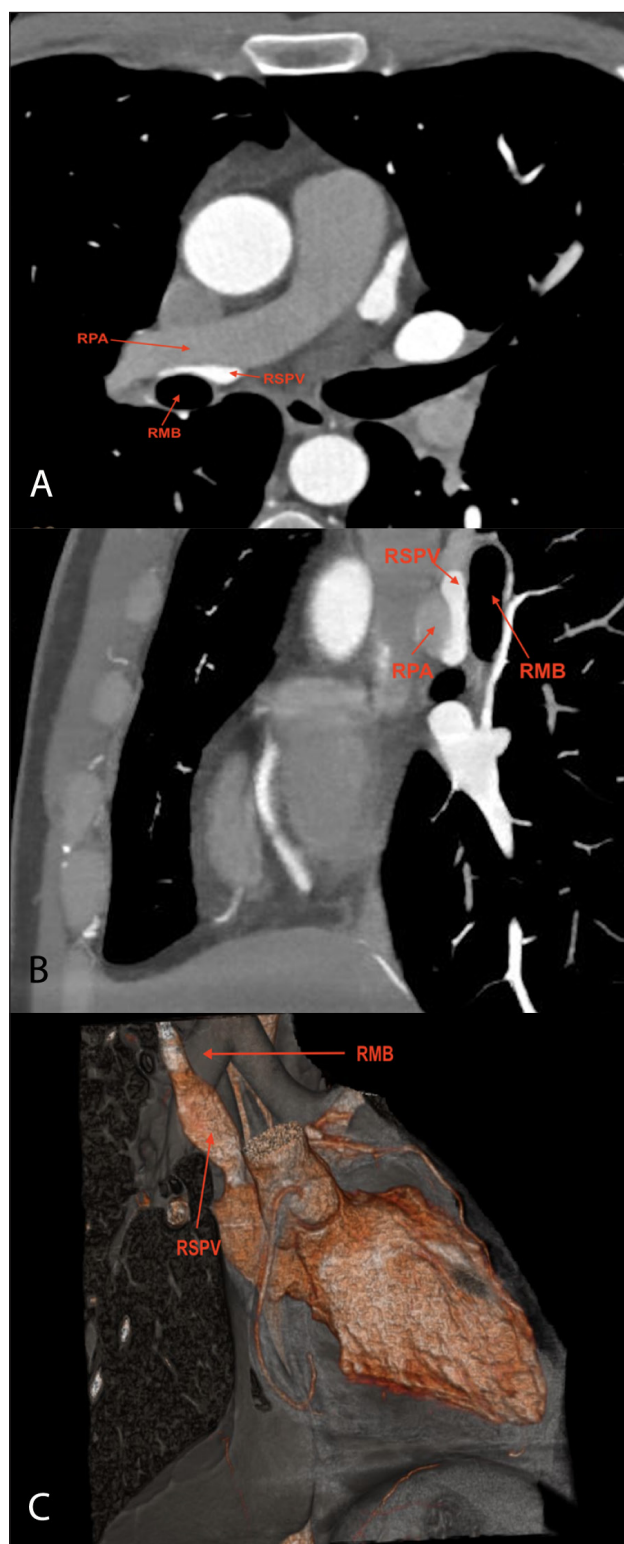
(A) A contrast-enhanced axial chest computed tomography (CT) scan shows the right superior pulmonary vein (RSPV) is aberrantly coursing between the right pulmonary artery (RPA) and the right main bronchus (RMB), and it is compressed in this anatomical configuration. (B) A contrast-enhanced chest CT image shows the RSPV compressed between the RPA and RMB. (C) A 3-dimensional CT image shows the RSPV anterior to the RMB and flattened due to compression by the RPA and RMB.
